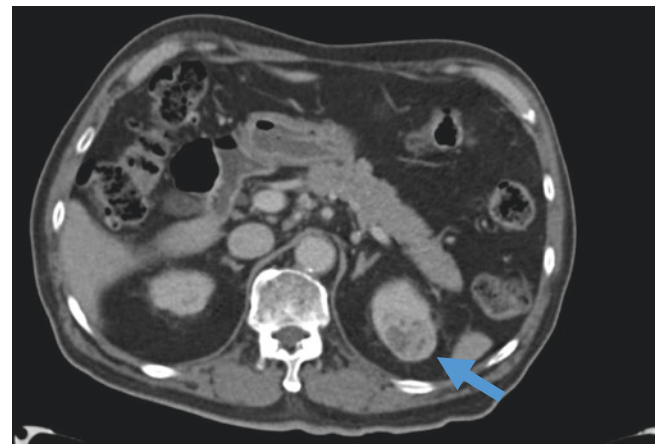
Contrast-enhanced CT scan of the abdomen of an 83-year-old man revealed an ill-defined, isodense, heterogeneously enhancing, solid nodule at the upper pole of the left kidney (arrow), measuring 3 × 2.7 × 3 cm (craniocaudal × transverse × anteroposterior)
